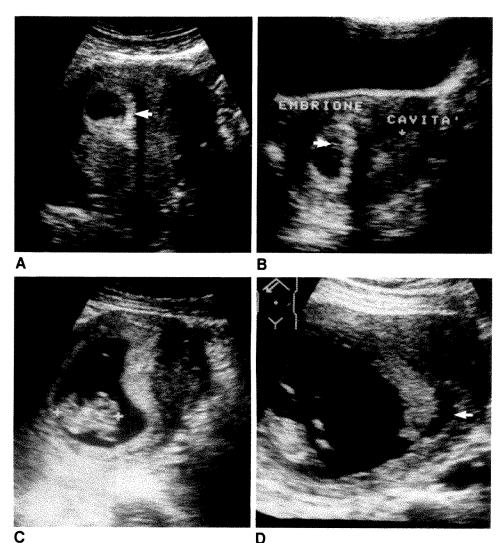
Sonograms show course of pregnancy with septal implantation in septate uterus.
